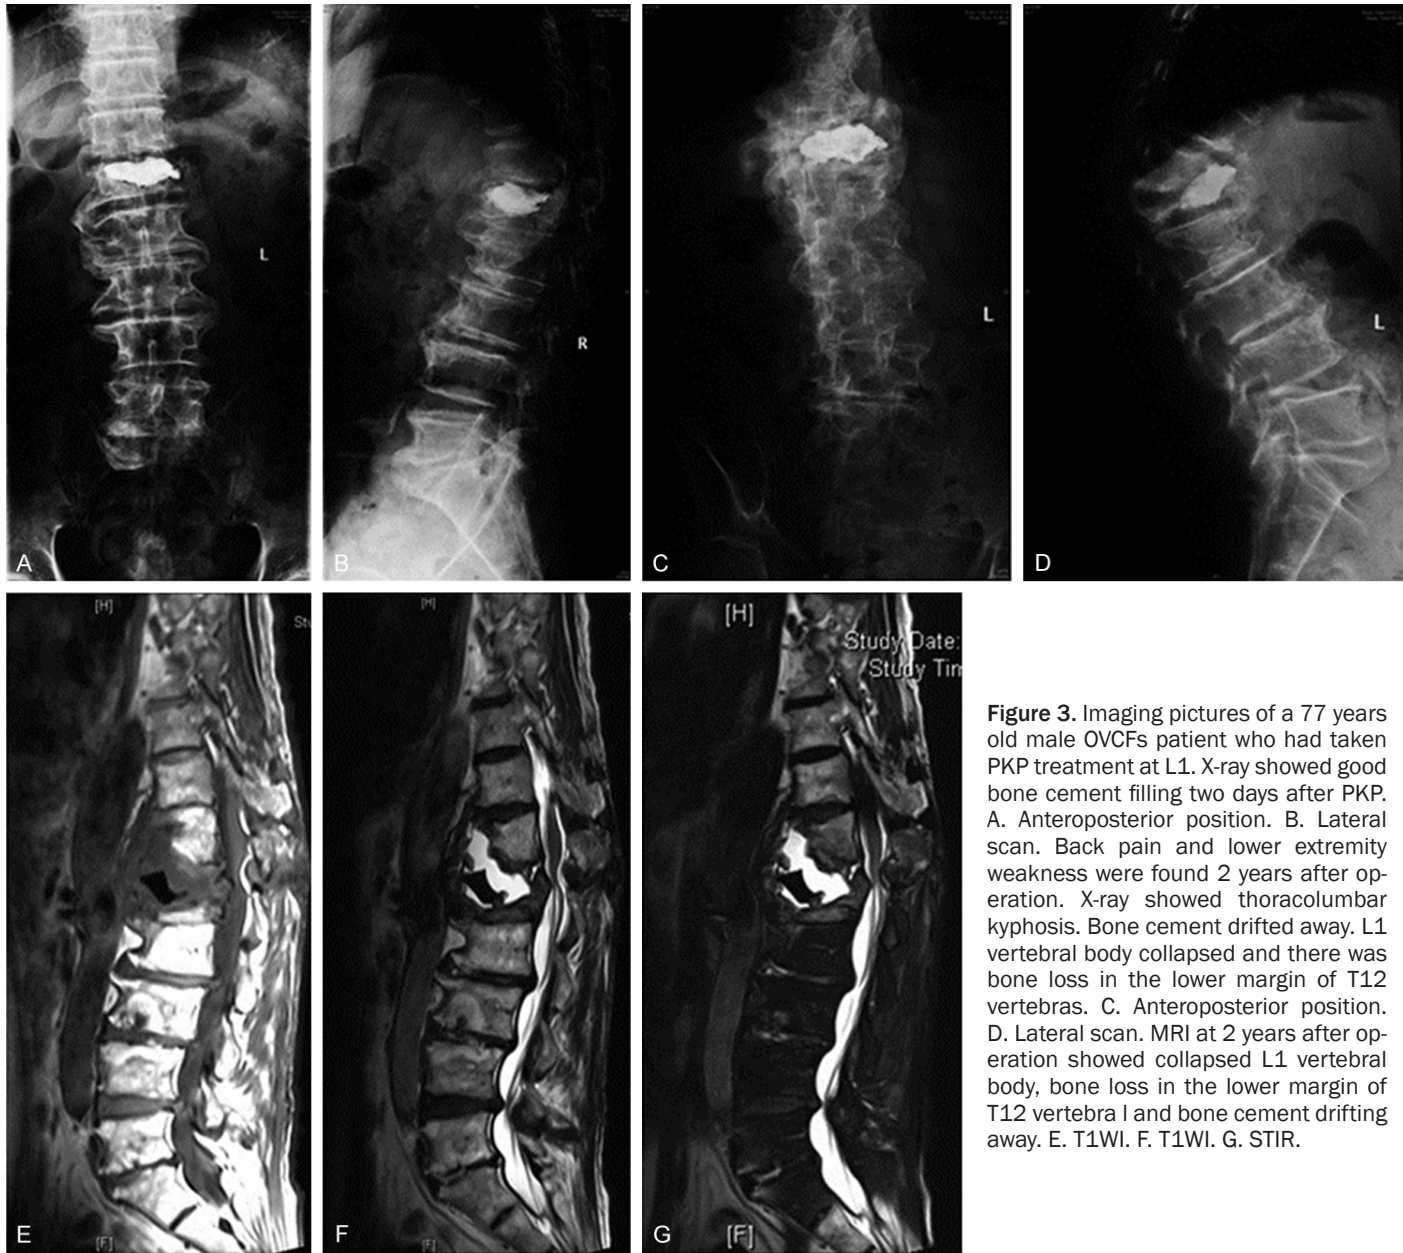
Imaging pictures of a 77 years old male OVCs patient who had taken PKP treatment at L1. X-ray showed good bone cement filling two days after PKP. A. Anteroposterior position. B. Lateral scan. Back pain and lower extremity weakness were found 2 years after operation. X-ray showed thoracolumbar kyphosis. Bone cement drifted away. L1 vertebral body collapsed and there was bone loss in the lower margin of T12 vertebrae. C. Anteroposterior position. D. Lateral scan. MRI at 2 years after operation showed collapsed L1 vertebral body, bone loss in the lower margin of T12 vertebra and bone cement drifting away. E. T1WI. F. T1WI. G. STIR.
